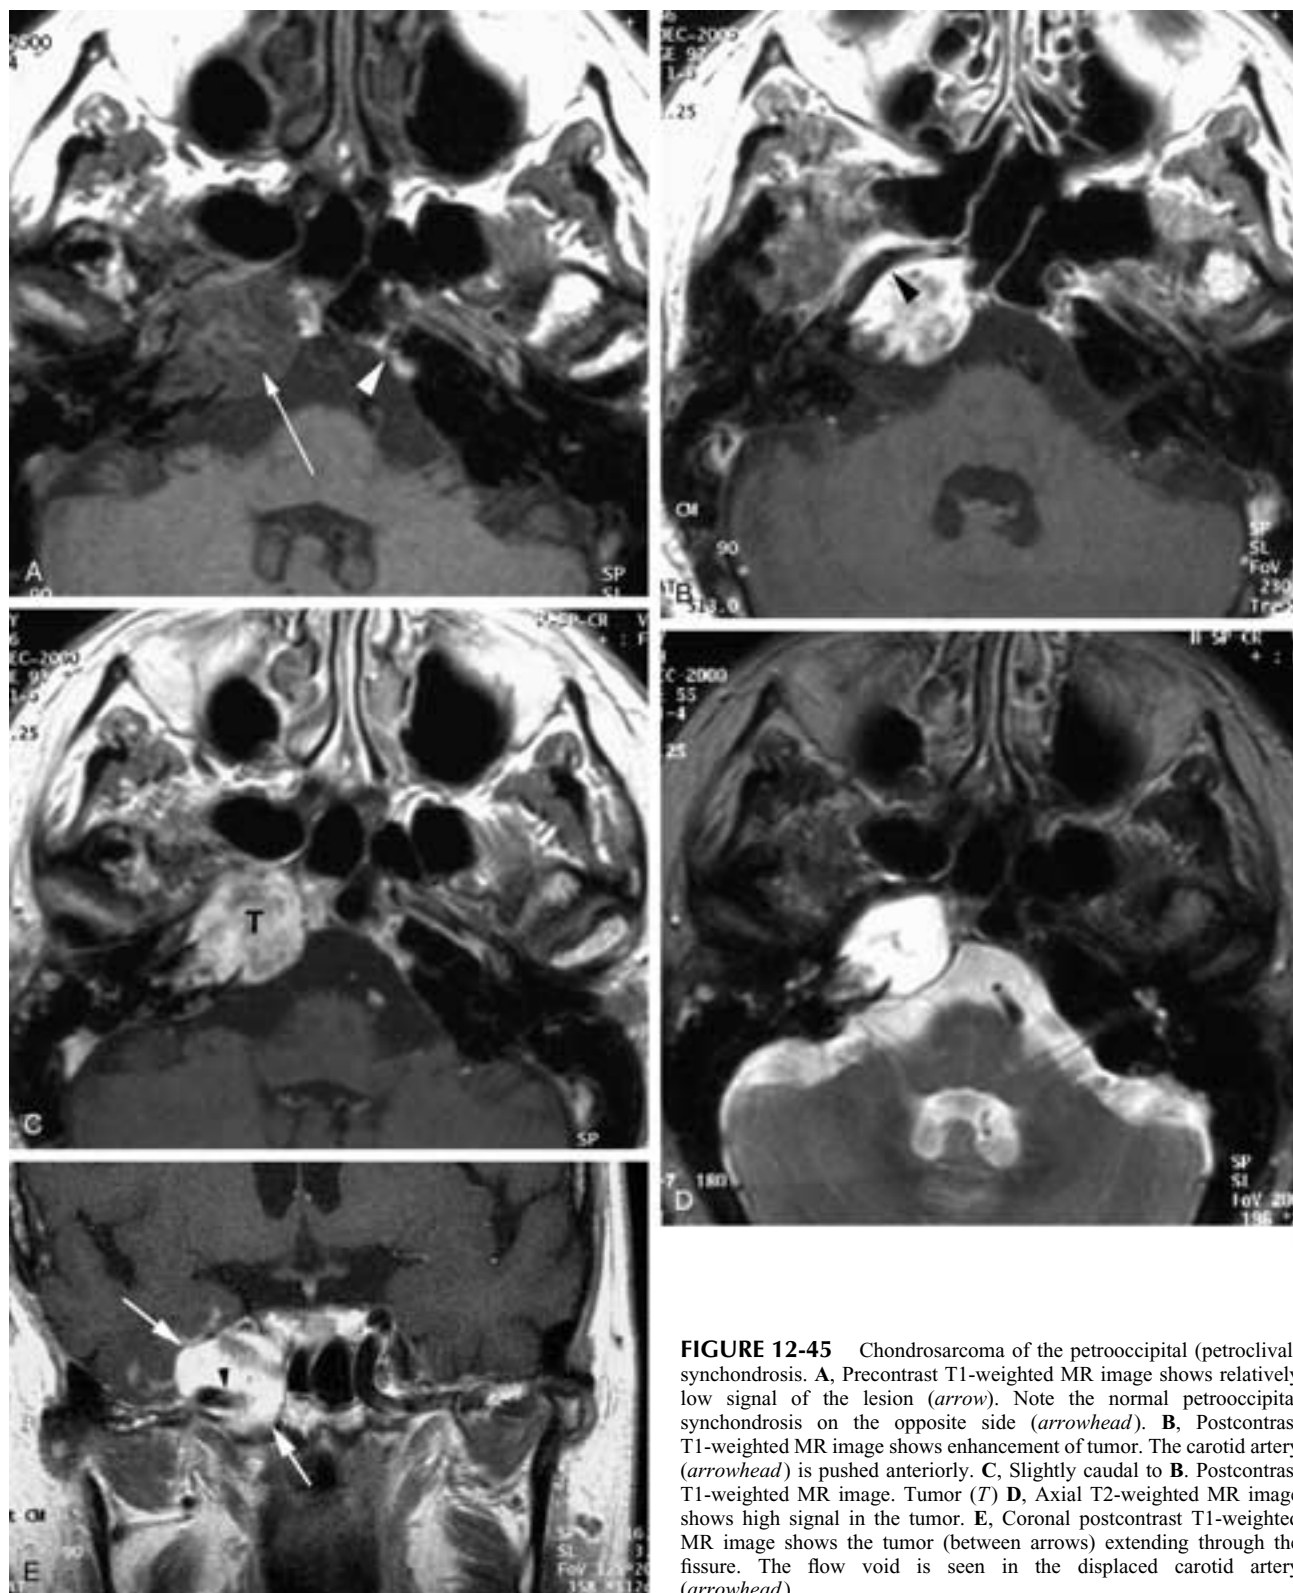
Chondrosarcoma of the petrooccipital (petroclival) synchondrosis. A, Precontrast T1-weighted MR image shows relatively low signal of the lesion (*arrow*). Note the normal petrooccipital synchondrosis on the opposite side (*arrowhead*). B, Postcontrast T1-weighted MR image shows enhancement of tumor. The carotid artery (*arrowhead*) is pushed anteriorly. C, Slightly caudal to B. Postcontrast T1-weighted MR image. Tumor (*T*). D, Axial T2-weighted MR image shows high signal in the tumor. E, Coronal postcontrast T1-weighted MR image shows the tumor (between arrows) extending through the fissure. The flow void is seen in the displaced carotid artery (*arrowhead*).
